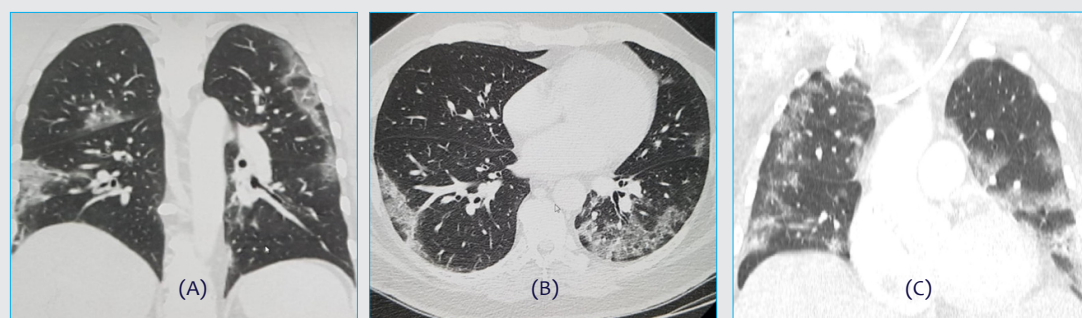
A coronal (A) and axial (B) sections of a CT scan of a patient with COVID-19 shows bilateral peripheral patchy opacifications. (C) A coronal section of another patient showing the same features.
